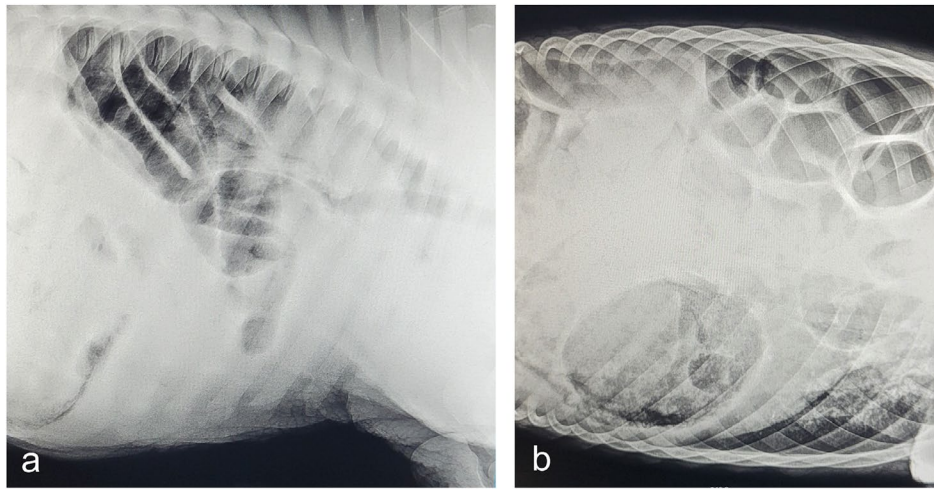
Diagnostic imaging: X-Ray (a) and CT (b) showing gas-filled intestinal loops within the thoracic cavity.
